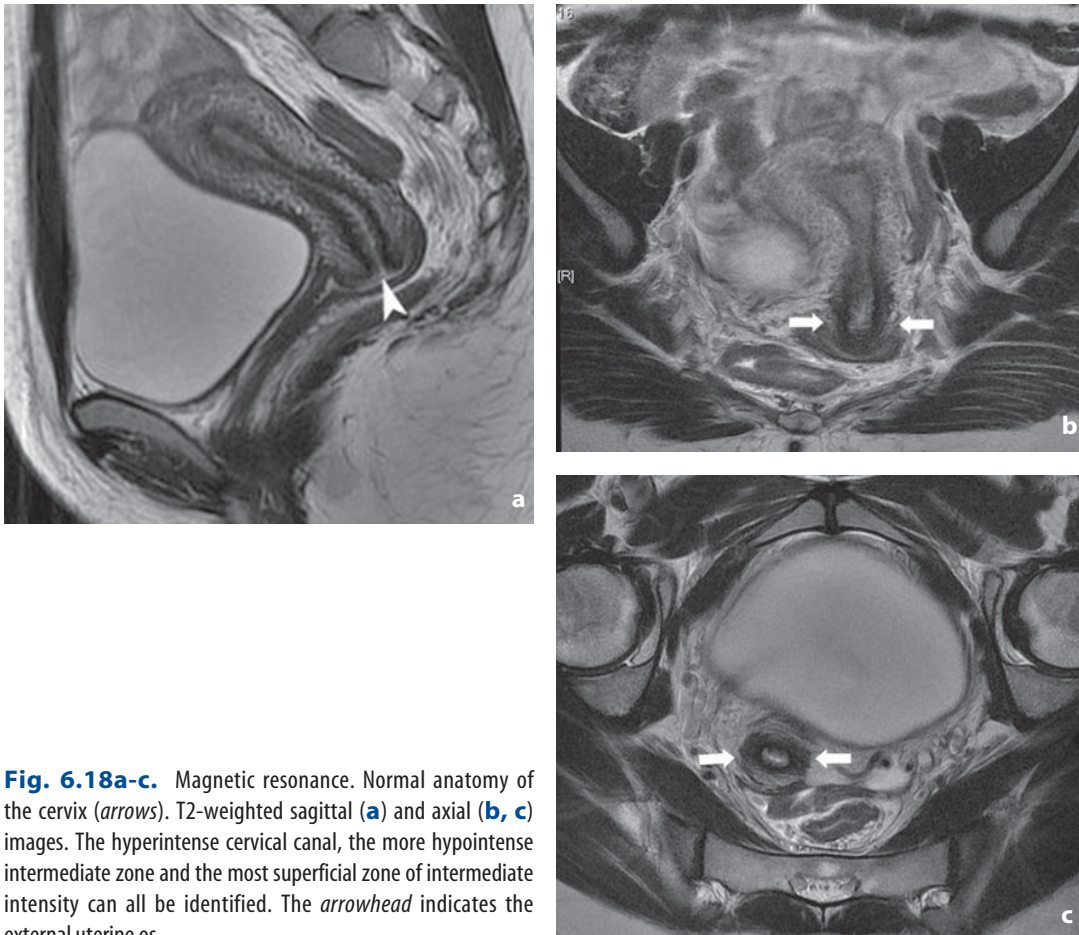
Magnetic resonance. Normal anatomy of the cervix (*arrows*). T2-weighted sagittal (a) and axial (b, c) images. The hyperintense cervical canal, the more hypointense intermediate zone and the most superficial zone of intermediate intensity can all be identified. The *arrowhead* indicates the external uterine os
